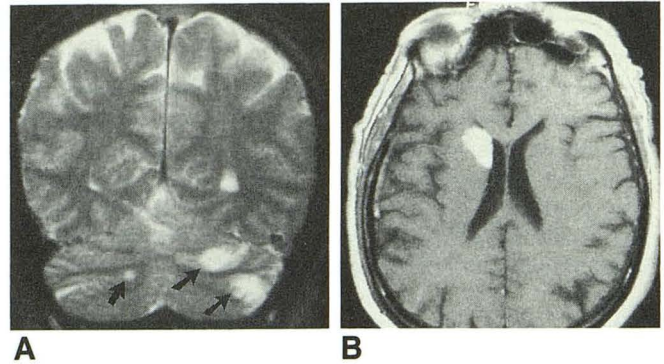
MR images obtained after cerebral angiography show clinically silent brain infarcts in two patients.
